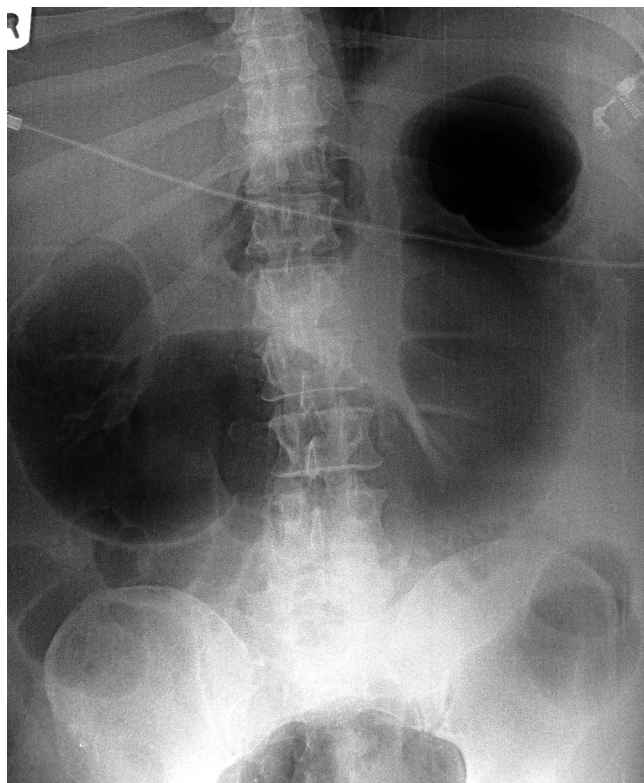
■ Plain abdominal radiograph of a patient with Ogilvie's syndrome 11 days after surgery for a ruptured aneurysm of the abdominal aorta. Dilatation (probably due to ischemia) is present in both the right and left colon. The syndrome was resolved with vasodilators and intravenous neostigmine.
